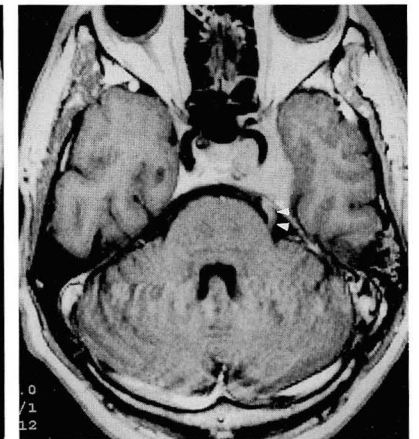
Petroclival extension of the dural tail. Enhanced T1-weighted MR image demonstrates the dural tail along the ridge of the right petroclivus (arrow heads).
